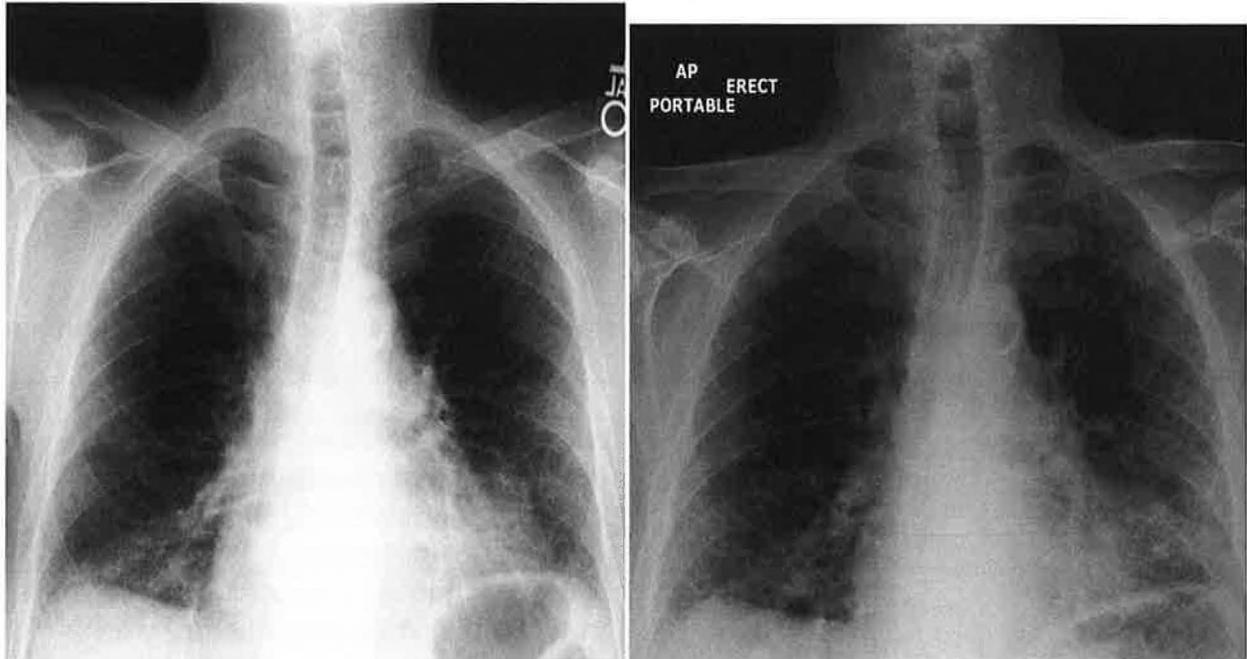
A) PA chest x-ray demonstrating the typical lower lobe predominant reticular infiltrate of asbestosis. B) follow-up film obtained from the same patient 6 years later demonstrating slow progression.
